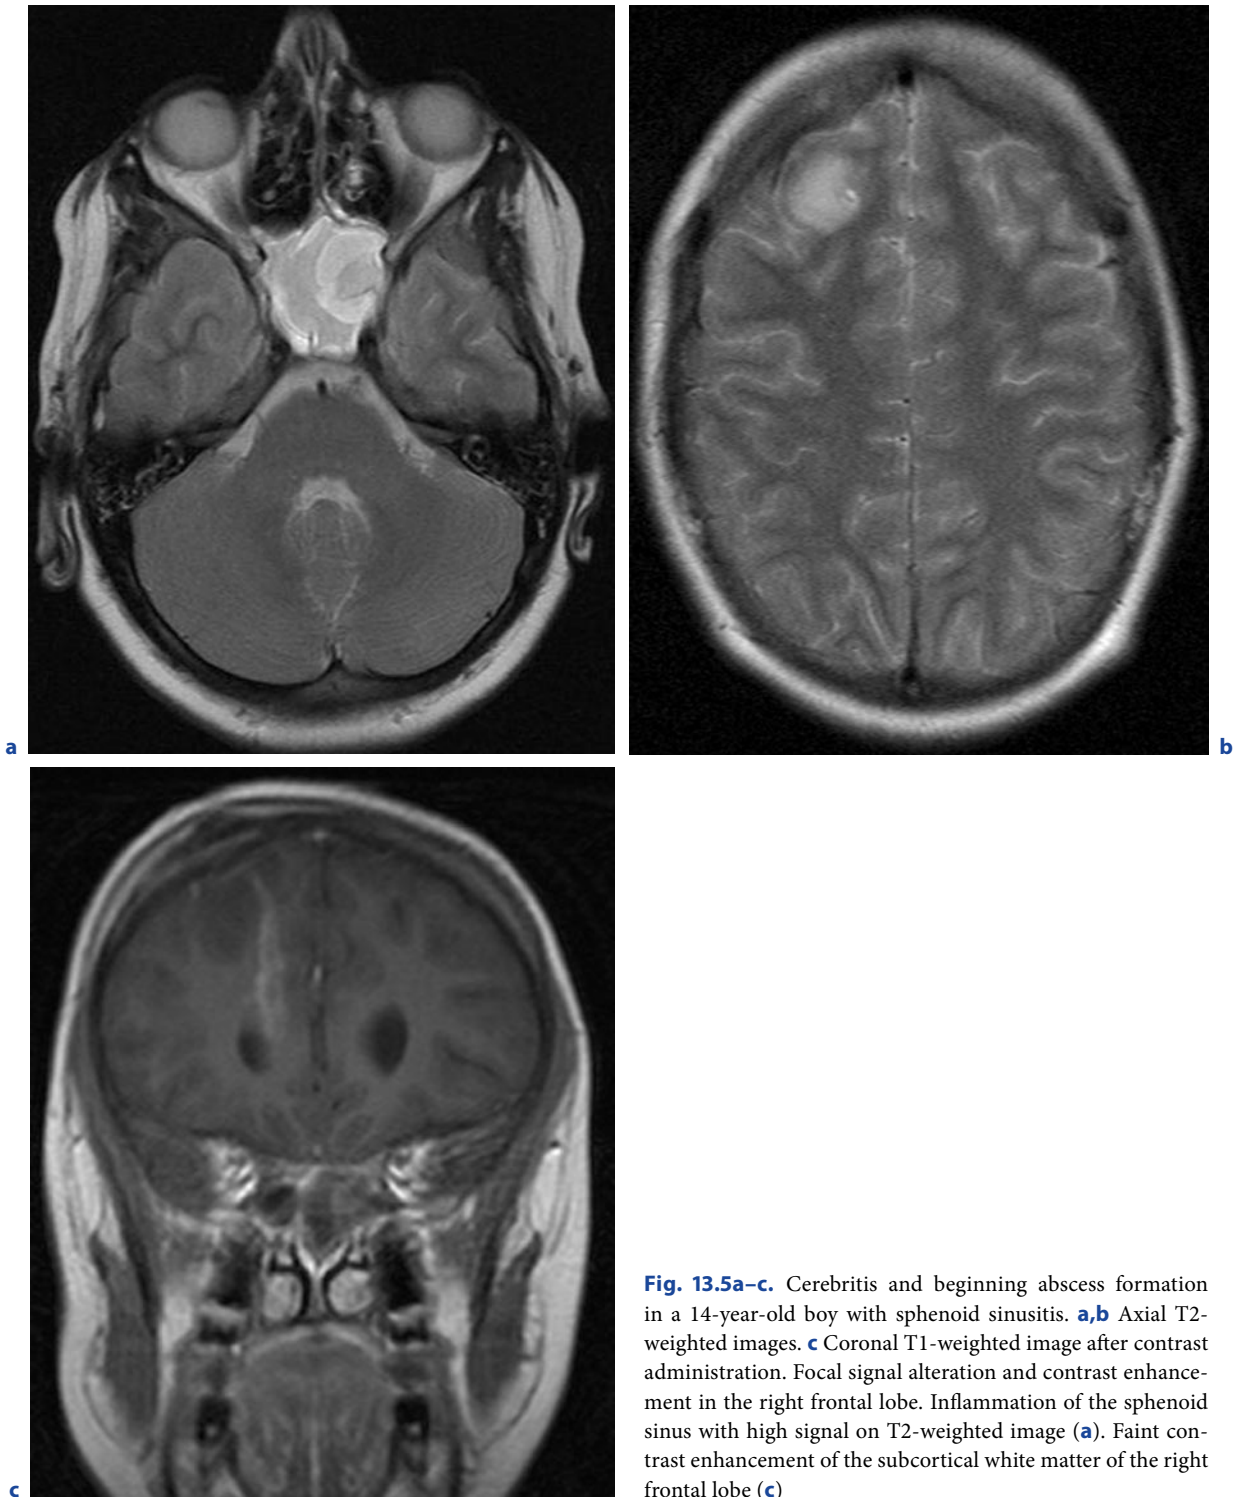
Cerebritis and beginning abscess formation in a 14-year-old boy with sphenoid sinusitis. a,b Axial T2-weighted images. c Coronal T1-weighted image after contrast administration. Focal signal alteration and contrast enhancement in the right frontal lobe. Inflammation of the sphenoid sinus with high signal on T2-weighted image (a). Faint contrast enhancement of the subcortical white matter of the right frontal lobe (c)
